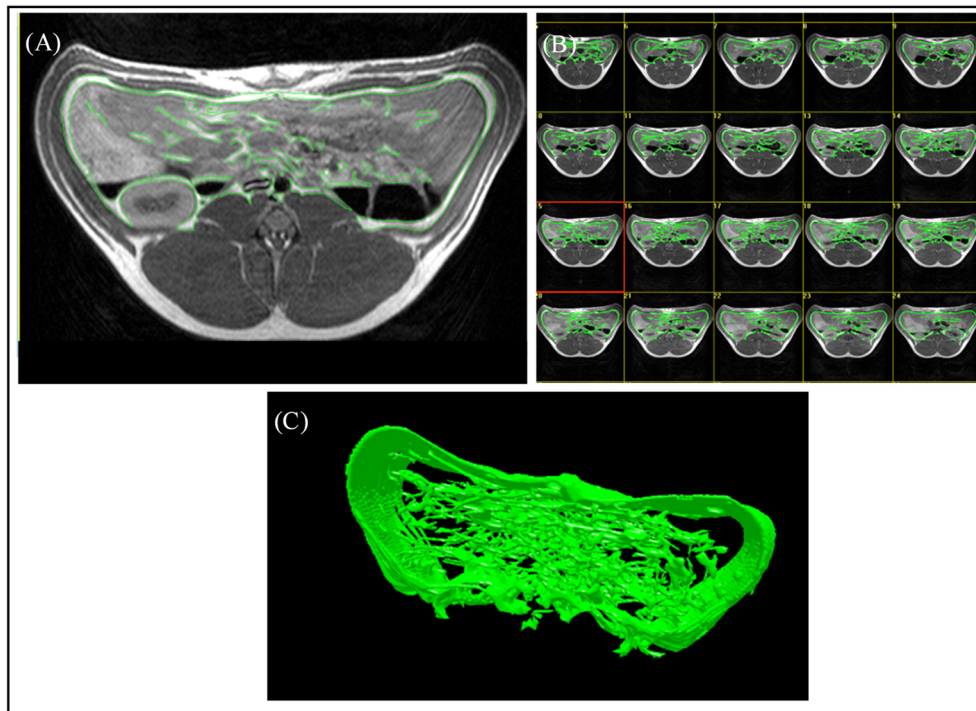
Evaluation of MR images using the Able 3D-Doctor[®] software. (A) T1-weighted axial MR image with green boundaries, including the visceral adipose tissue. (B) Analysis of all slices in the defined body region. (C) Reconstruction of a 3D-model from the selected boundaries of VAT.
